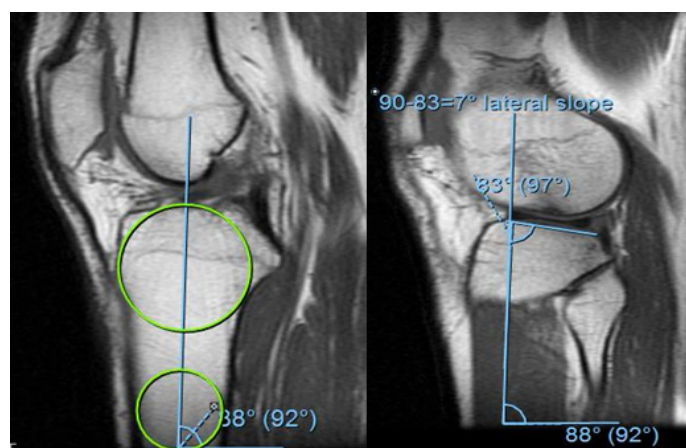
Measurement of LPTS in MRI
